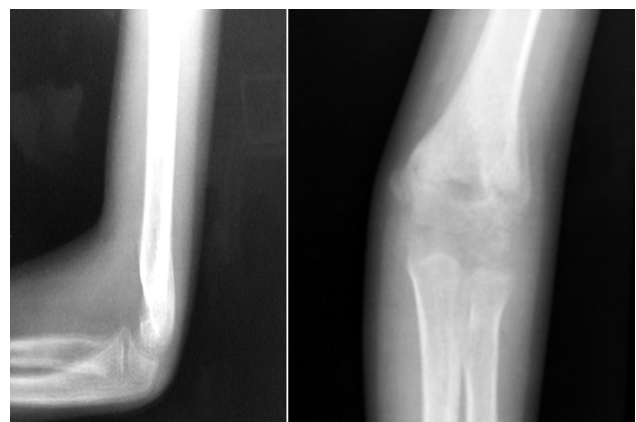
Follow up X-rays of elbow – AP and lateral views, after K-wires removal.
